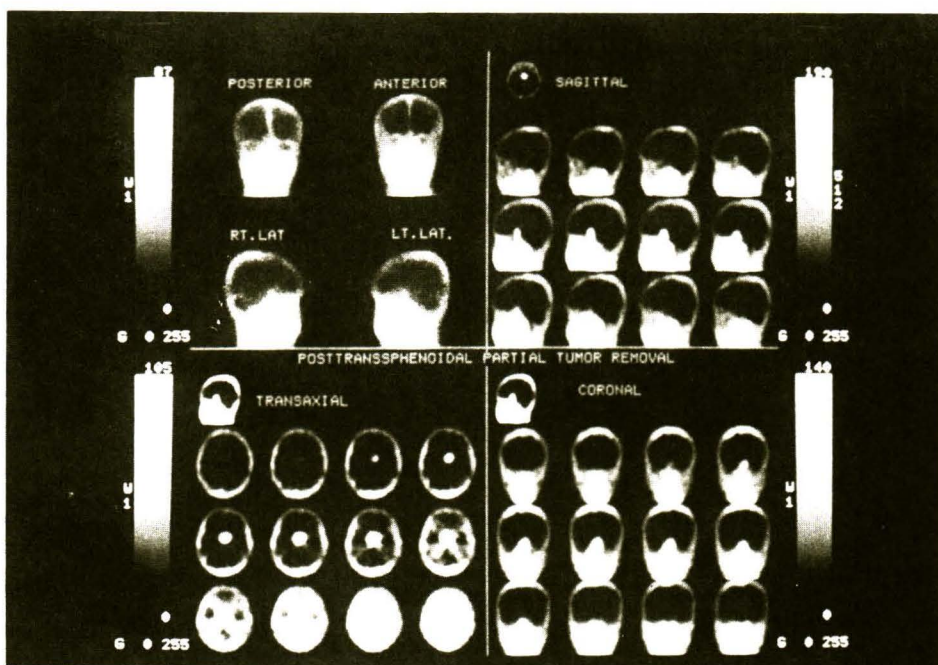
Planar and SPECT images at skull after transphenoidal partial tumor removal showed residual tumor uptake of ^{99m}Tc P829 in the same patient as Fig. 1.
